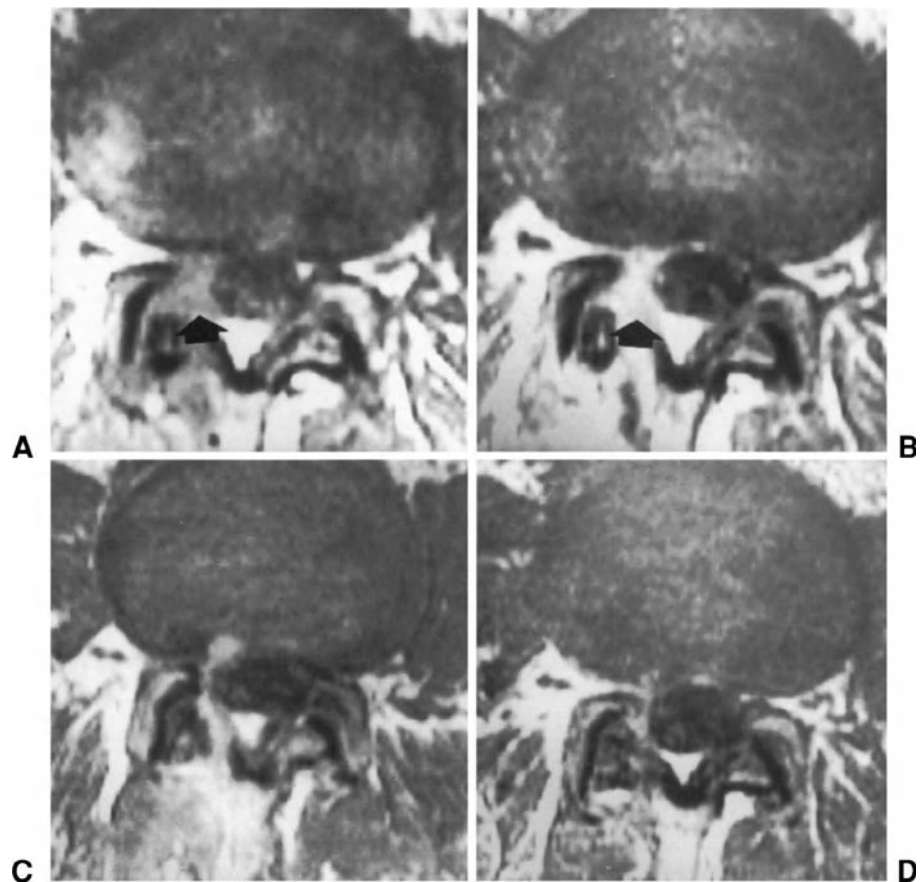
Spin-echo T1-weighted MR images without contrast (A) and after administration of gadolinium (B) obtained 7 days after discectomy on the right side, and images without contrast medium (C) and after injection of gadolinium (D) obtained 3 months after surgery. The decrease in amount of hyperintense tissue at the site of surgery (arrows) between 7 days and 3 months is due to normal postsurgical resorption of the tissue.
